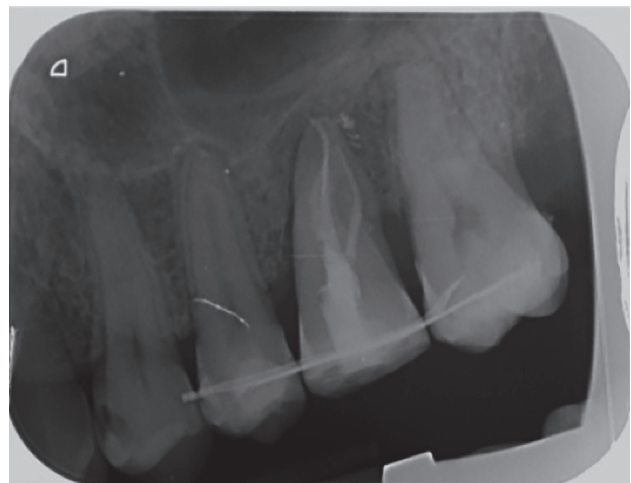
Parallel periapical radiograph at 3 weeks after the autotransplant, coinciding with the duct treatment.
